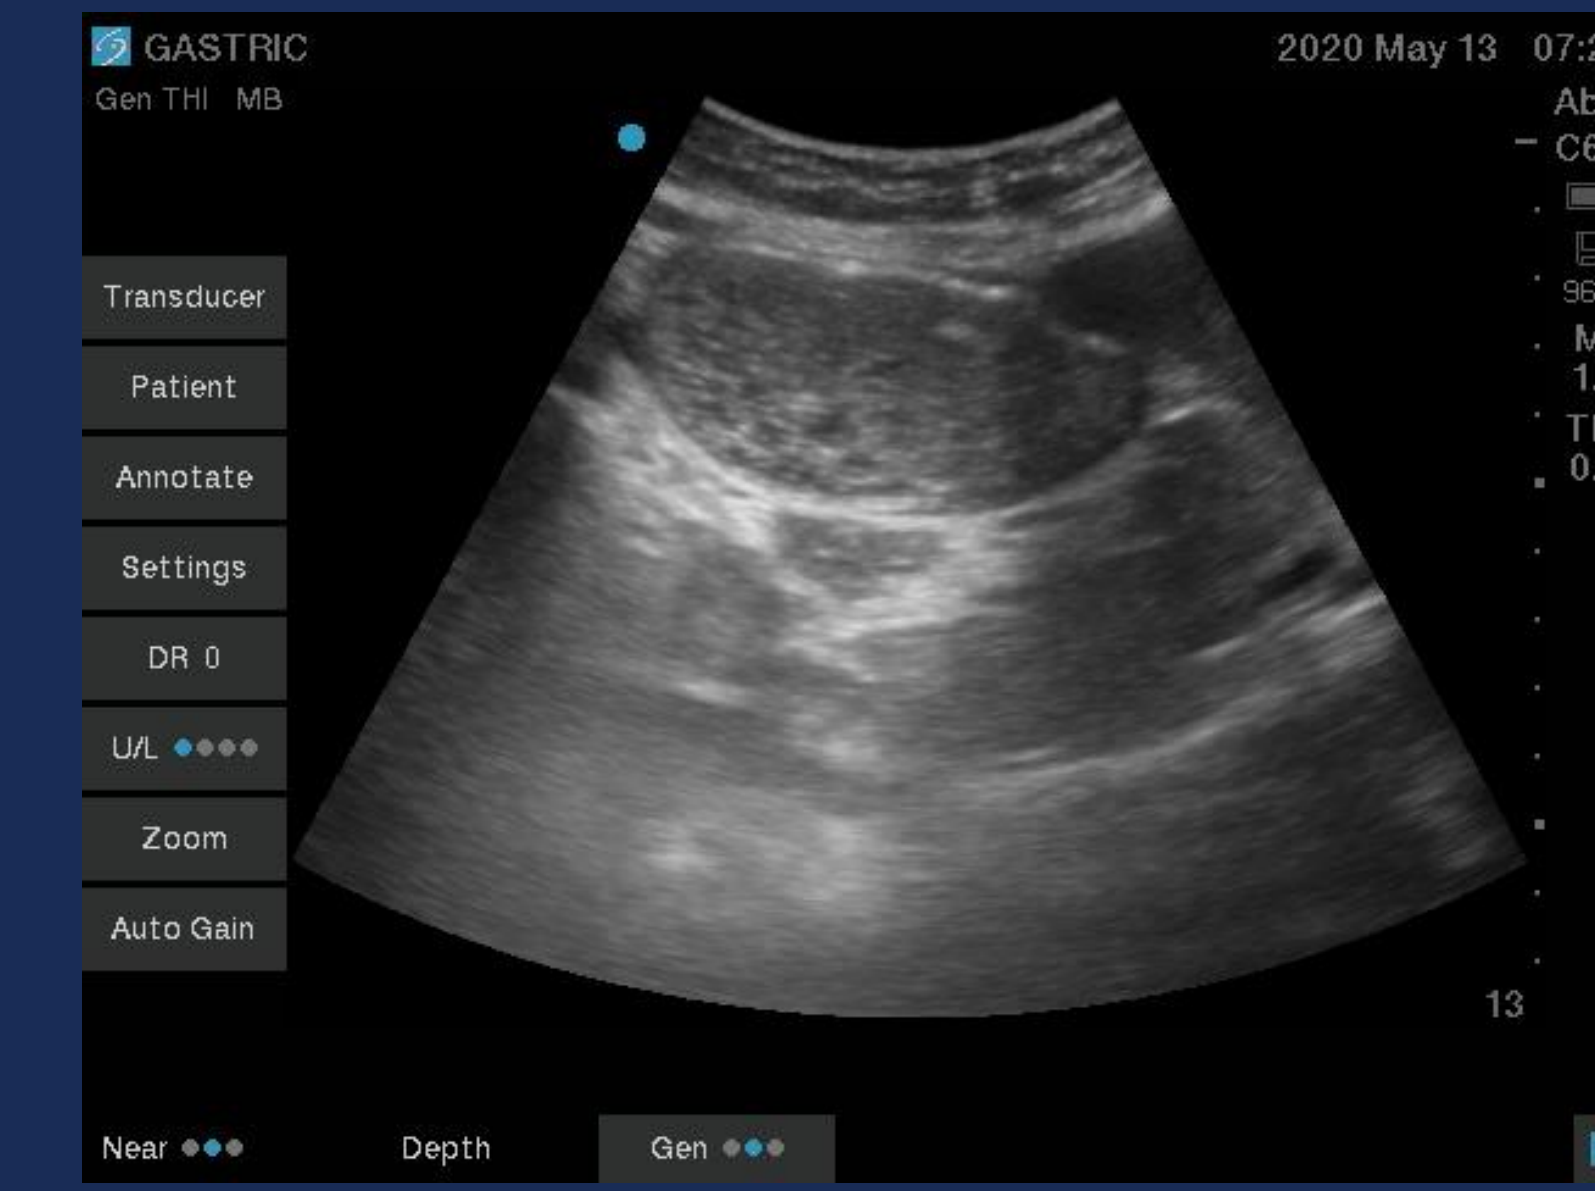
Ultrasound image of the gastric antrum in right lateral decubitus position immediately after ingesting 8-ounces of orange juice with pulp
